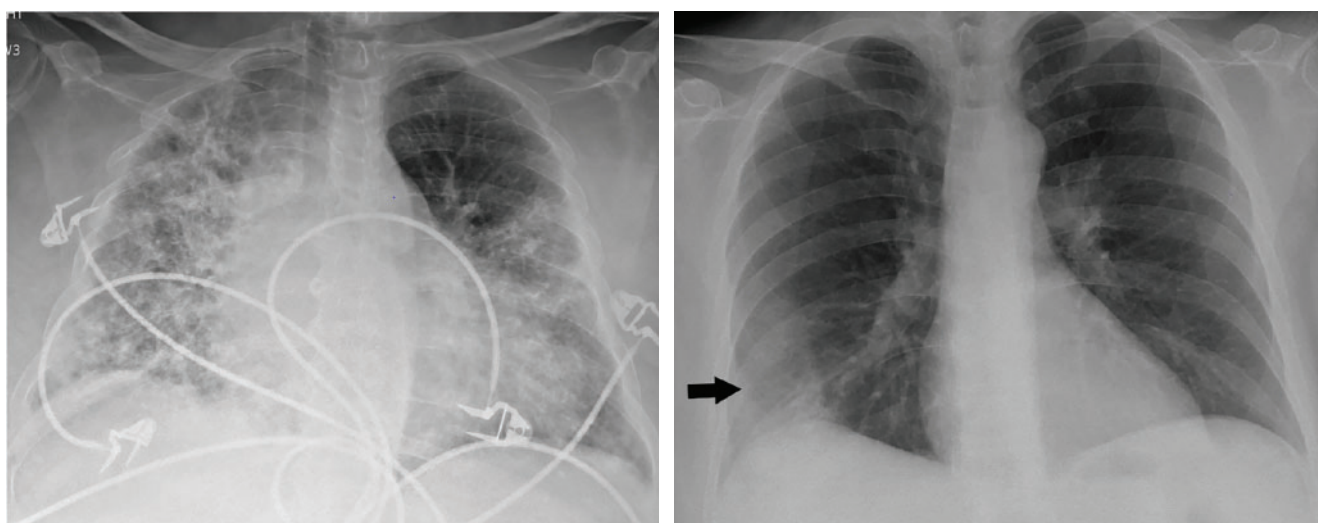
Portable chest radiographs of patients with COVID-19 demonstrating atypical features of diffuse bilateral interstitial changes (A) and unilateral consolidation (B).
